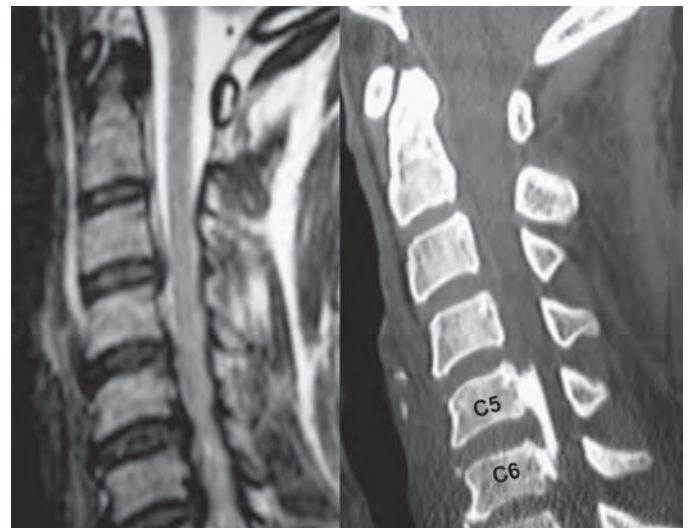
MRI and CT scan showing cervical canal stenosis due to anterior compression by opacified posterior longitudinal ligament
